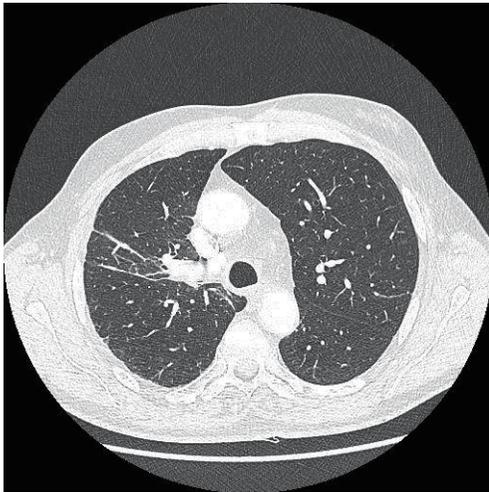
CT scan shows tumour in the right lung measuring 52×30 mm. No enlarged mediastinal lymph nodes.
